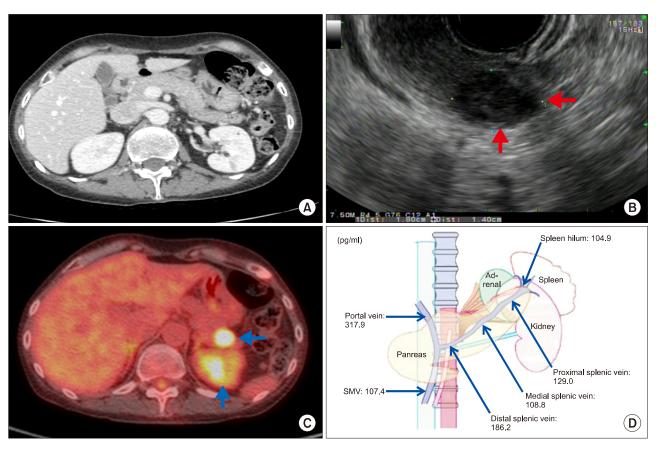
Preoperative findings. (A) Adrenal Computed Tomography: No remarkable finding in both adrenal glands. (B) Endoscopic ultrasonography: 18 mm-sized solid mass was localized to the pancreatic tail. Echo intensity was hypoechoic and echo texture was homogenous (black arrows). (C) Uptake at the pancreatic tail in positron emission tomography (white arrows). (D) ACTH sampling from the pancreatic, splenic, and portal vein.
